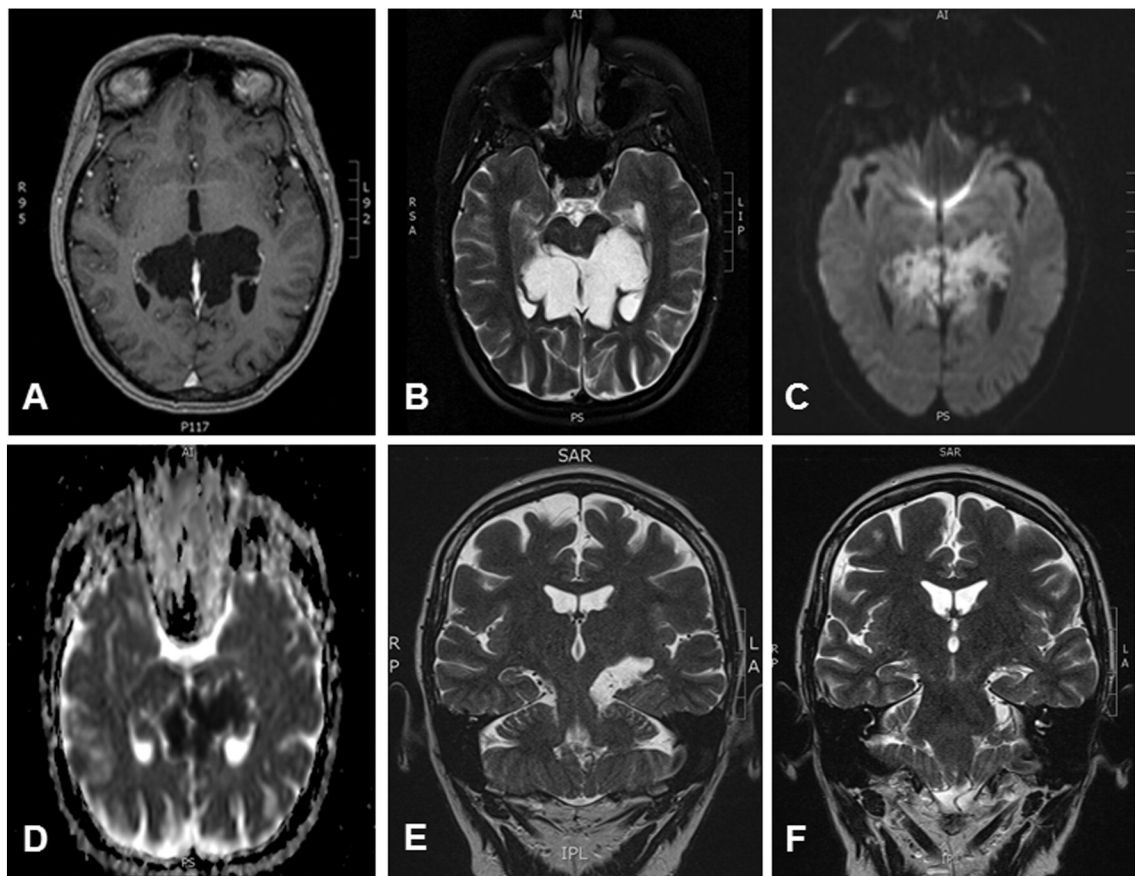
Preoperative brain MRI demonstrates a mass lesion located in the left quadrigeminal plate cistern compressing the cerebellar vermis and tail of the left hippocampus. The epidermoid exhibits typical imaging findings on axial (A) T1 (low signal), (B) T2 (high signal), (C) bright signal on the diffusion-weighted image B1000, (D) dark signal/restricted diffusion on the ADC, (E) coronal T2-weighted images demonstrate involvement of the tail of the left hippocampus, and (F) the left mesial temporal sclerosis demonstrated by an atrophic hippocampus with hyperintense T2 signal. There is no edematous reaction or fluid collection in the surrounding tissues; no evidence of intracranial hemorrhage or acute infarct.
